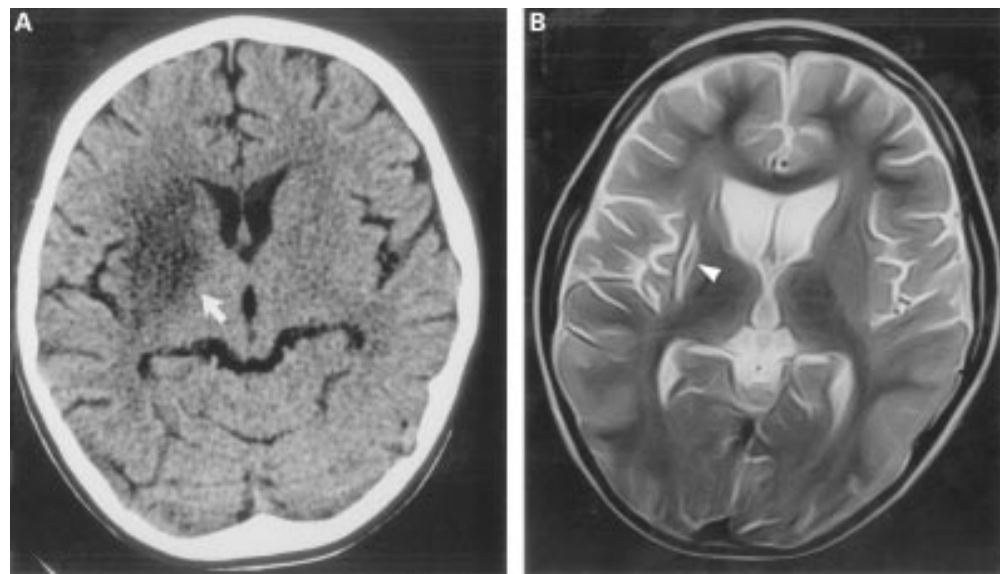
(A) Transverse axial computed tomogram on day 14 of his admission shows marked radiolucency in the right lentiform nucleus (arrow). (B) Transverse axial T2 weighted magnetic resonance imaging three months after admission shows atrophy of both caudate nuclei with enlargement of the adjacent lateral ventricles. The right putamen is small (arrowhead) and shows focal hyperintensity which could be due to methaemoglobin or early calcification.
